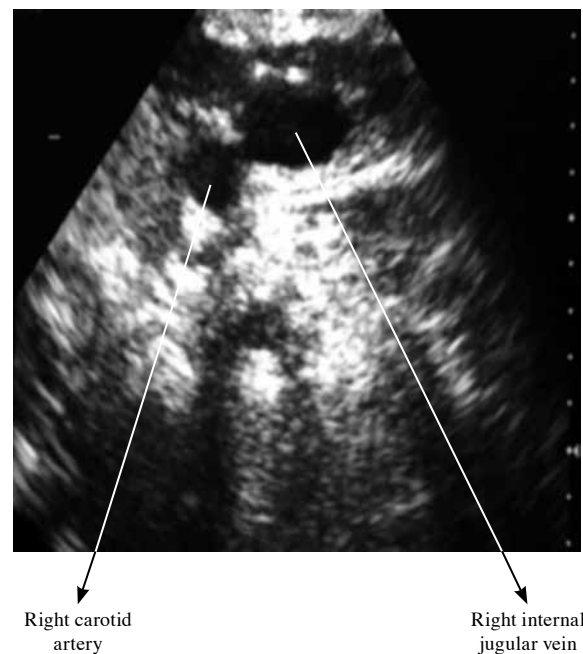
Two-dimensional ultrasound image of right femoral vein. Right neck central vein cannulation. Out-of-plane (short axis) ultrasound image.
